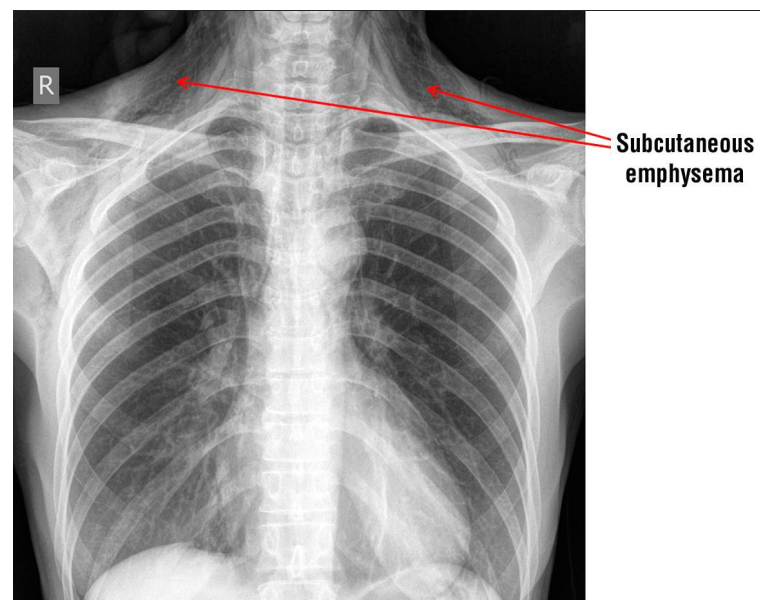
Chest radiography after presentation of subcutaneous emphysema
